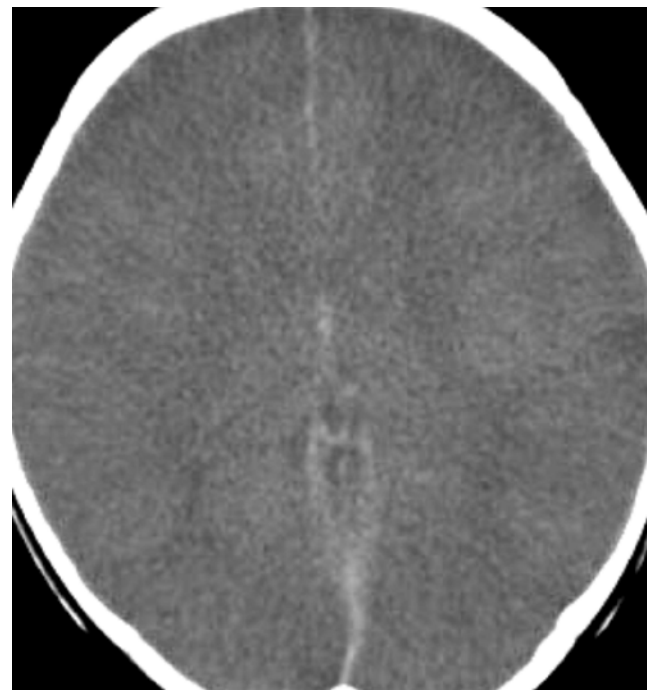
Follow-up brain CT images on the second day of admission show diffuse brain swelling with ventricle collapse.
